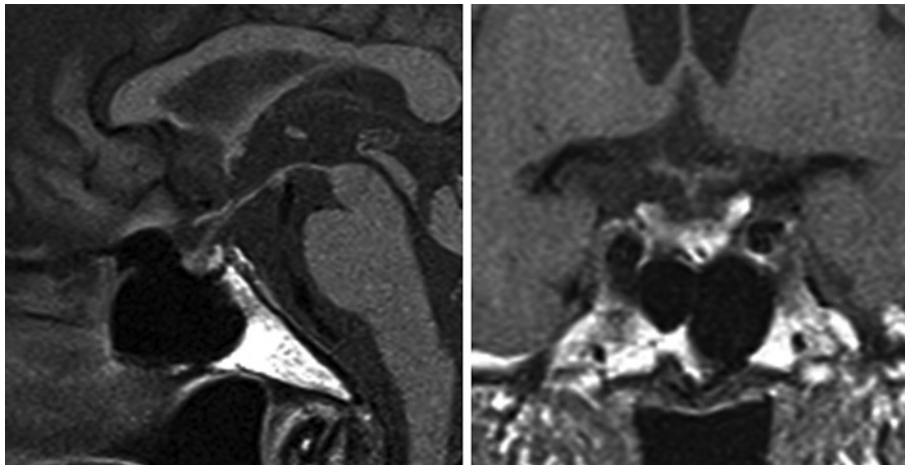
Sagittal and coronal sections of T1-weighted MRI taken 8 days after hospital admission. The pituitary gland was not enlarged (height, 5.8 mm; length, 9.7 mm; width, 9.3 mm).
